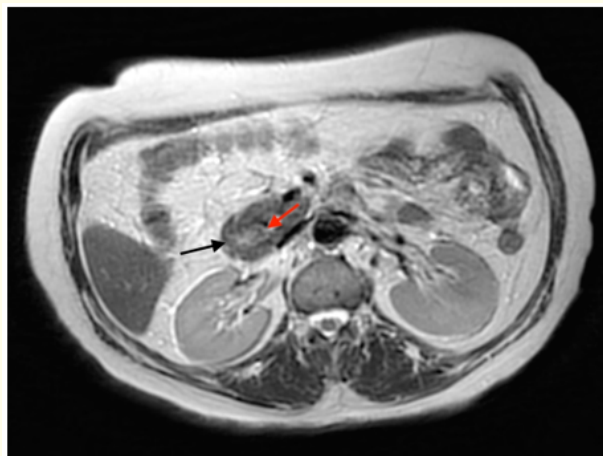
Axial T2-weighted cholangio-pancreatic MRI demonstrating pancreatic parenchyma (Black arrow) encircling the second portion of the duodenum (Red arrow).
